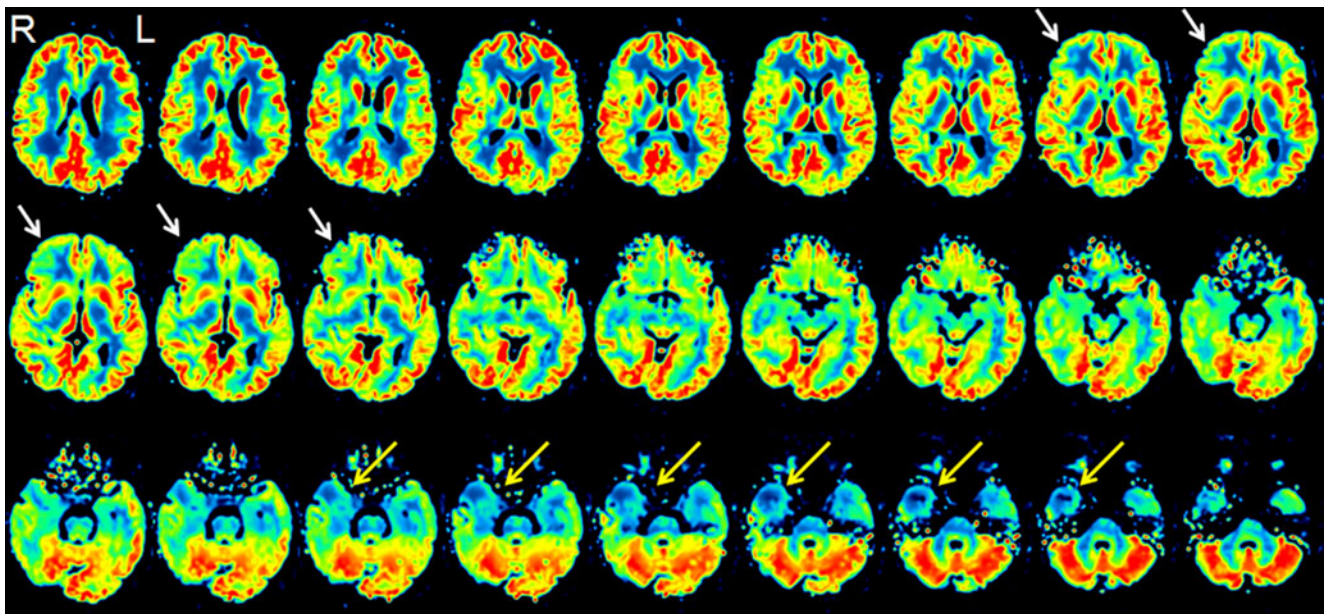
A-MAP reconstructed FDG-PET images from a patient with FCD in the right temporal cortex (patient 6) show clear hypometabolism (*yellow arrows*). Visual interpretation also shows a hypometabolic area
